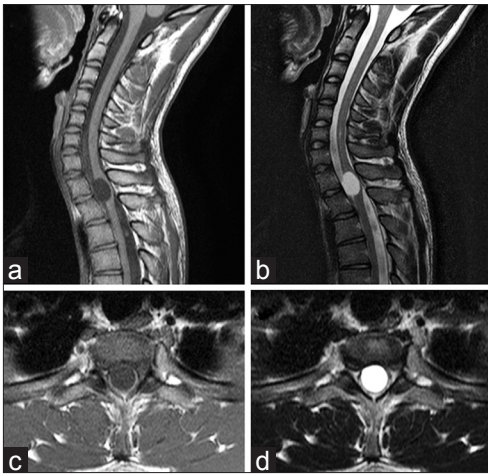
Preoperative T1-weighted (a, c) and T2-weighted (b, d) magnetic resonance images without gadolinium enhancement demonstrating an intradural extramedullary cystic tumor at the T1-T2 level. (a, b) Sagittal view and (c, d) axial view
